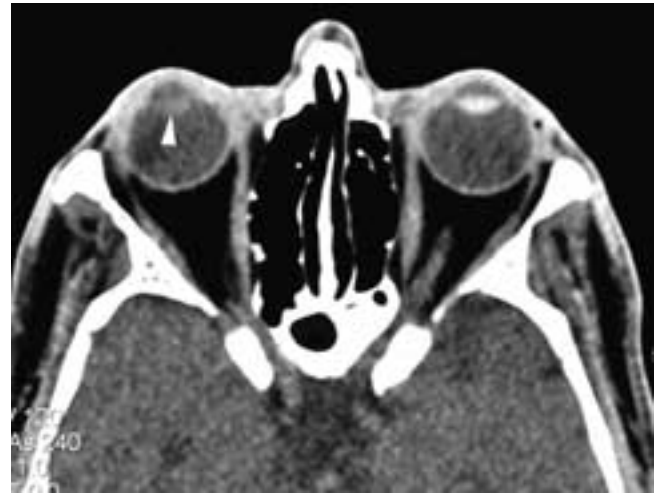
Axial CT. Acute perforation of the lens capsule. The abnormal lens (*arrowhead*) has low density due to the influx of fluid diluting the normally high protein of the lens. Compare with the opposite side.
